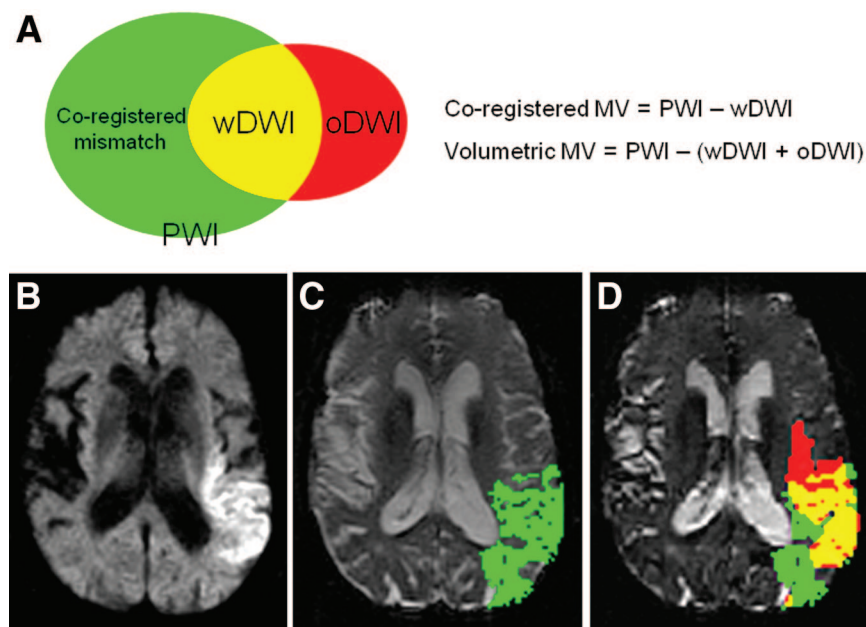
A, Coregistration of perfusion-weighted imaging (PWI) and diffusion-weighted imaging (DWI) allows the DWI lesion to be divided into 2 regions: DWI within (wDWI; yellow) and DWI lying outside the PWI lesion (oDWI; red). Using the volumetric technique, the mismatch volume (MV) is $PWI - (wDWI + oDWI)$, whereas the coregistered MV (green) is defined as $PWI - wDWI$. An 82-year-old woman with baseline MRI performed 325 minutes after stroke onset. The baseline DWI lesion volume was 65.3 mL (B) and PWI lesion volume was 68.8 mL (C; green areas indicate PWI abnormalities of T_{max} 2 seconds or more). In EPITHET using the volumetric technique, she was classified as having no mismatch (3.5 mL); however, while coregistered (D), she was classified as having mismatch (26.2 mL; wDWI in yellow, oDWI in red, and coregistered mismatch areas in green).
